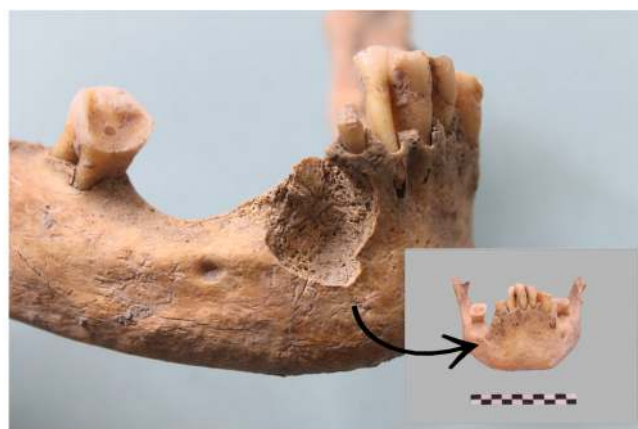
Male middle-aged adult right mandibular ramus and dentition showing the presence of severe AMTL, dental wear and periapical cavities; Tomb 65 of the Pontokomi skeletal assemblage, Kozani, Greece, 1st to 4th c. CE (photo by Vergidou C. with the kind permission of Dr. Karamitrou-Mentessidi).
